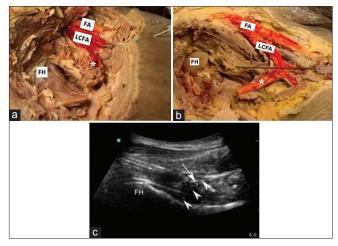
LCFA dissection in human cadavers. (a) Early branching of the transverse branch of LCFA – ultrasound-guided hip joint injection using anterior longitudinal approach with subsequent dissection. Needle comes in close proximity to the transverse branch of the LCFA (asterisk); FH and FA are also exposed. (b) Late branching of the transverse branch of LCFA. (c) Ultrasound of anterior longitudinal approach showing needle (arrowheads), femoral vessels (arrow), and FH. LCFA: Lateral circumflex femoral artery, FH: Femoral head, FA: Femoral artery
